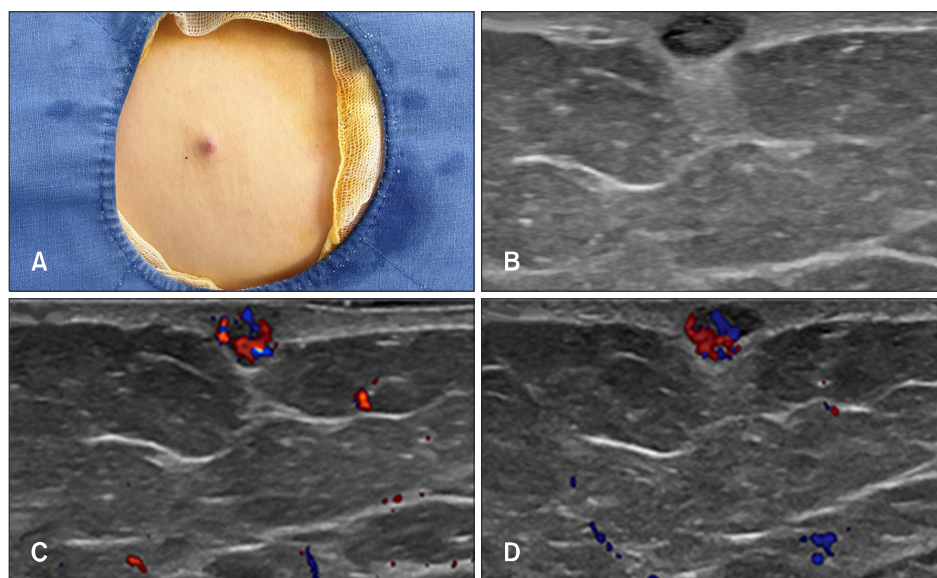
(A) A 62-year-old female patient presented with pain in the left anterior thigh. (B) Gray scale ultrasonography demonstrates a 0.8 cm × 0.6 cm sized nodule with a well-circumscribed, heterogenous character in the dermal layer. (C, D) Color Doppler ultrasonography reveals rich vasculature in the nodule. We received the patient's consent form about publishing all photographic materials.
